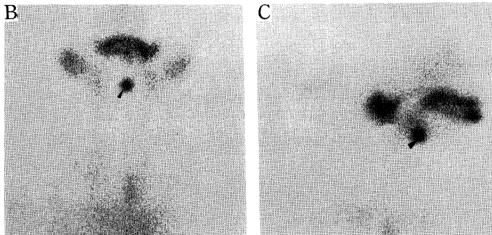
Case I. Radiograph (a) demonstrates coarse fragmentations in capital femoral epiphyses and flattened lumbar vertebrae with irregular margin. Anterior (b) and lateral (c) views of scintigraph using 99mTc pertechnetate reveal no activity over the neck and a focal intense activity at midline of the mandible and inferior to the oropharynx (arrowheads), indicating sublingual thyroid.
